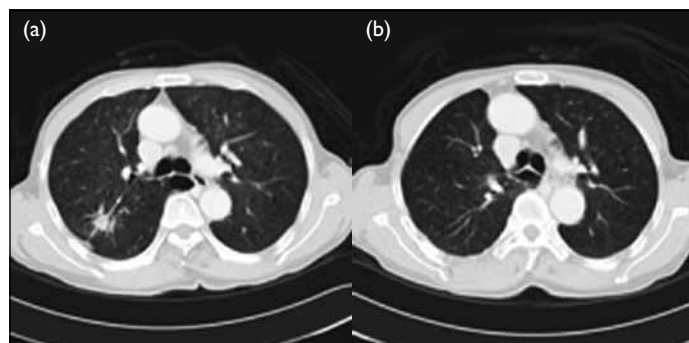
Contrast computed tomographic thorax images of patient 8 (a) before and (b) after lobectomy
